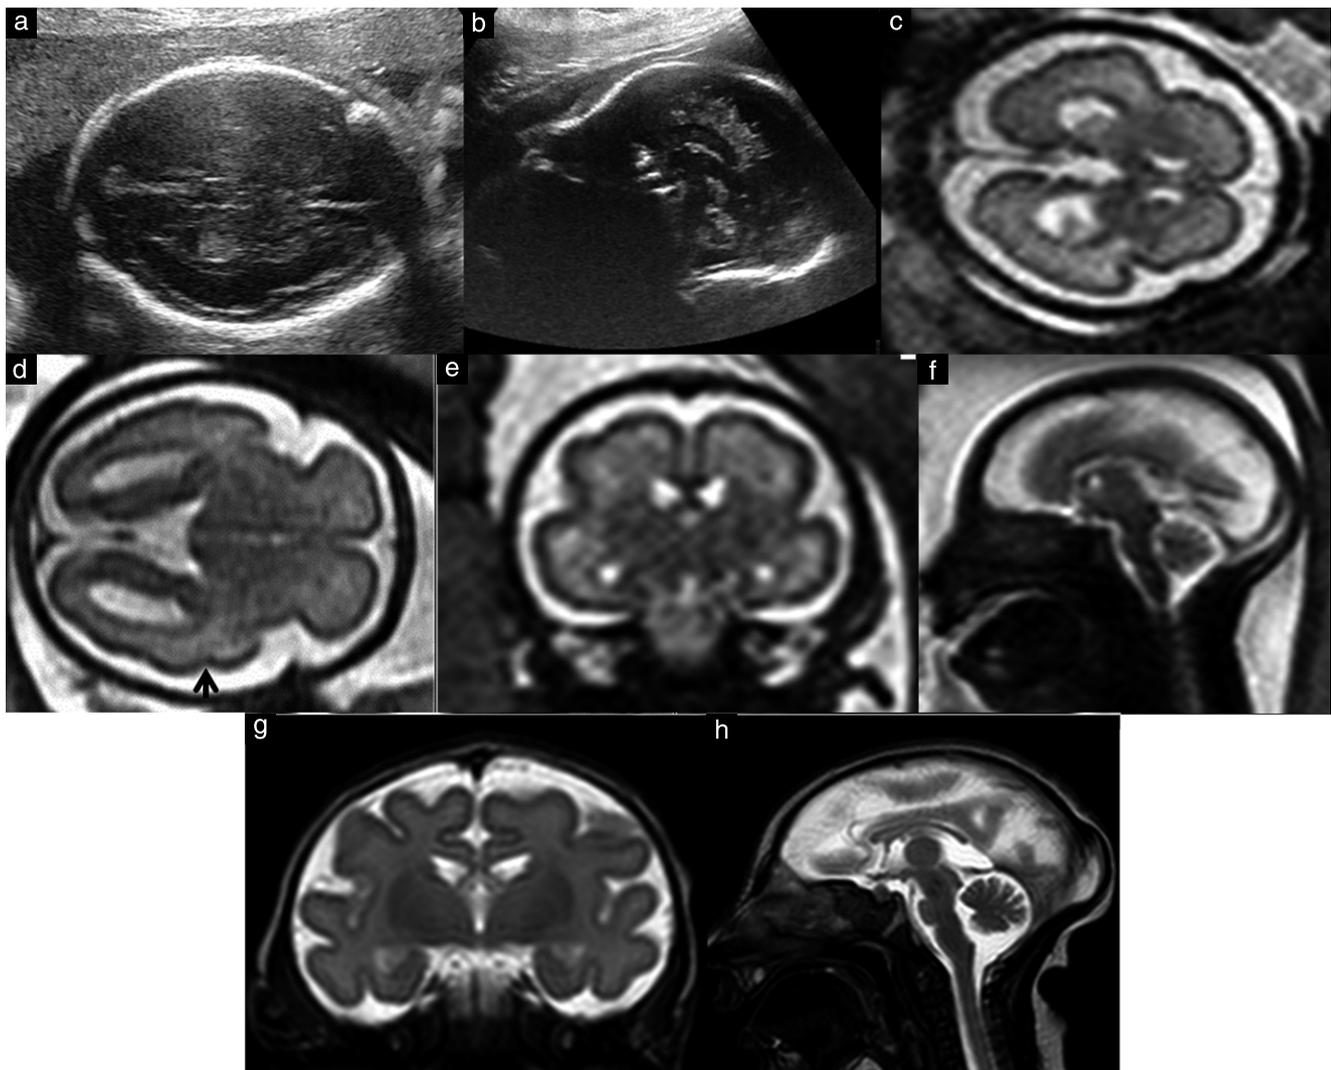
Fetal and postnatal imaging in a patient referred at 26 gestational weeks due to both a decrease in cephalic biometry and non-identification of the corpus callosum, with no context of consanguinity. At first sonographic examination, microcephaly was confirmed, with head circumference (HC) corresponding to the 50th percentile at 23 weeks, equivalent to a decrease of 2.5 SD, associated with normal extracerebral biometry. Axial (a) and mid-sagittal (b) sonographic images showing both smooth cortical surface with a lack of gyral pattern (a) and presence of thin complete corpus callosum (b). Sonographic follow-up at 28.3 weeks demonstrated severe, non-progressive microcephaly (delayed by 3 weeks according to cephalic biometry) without any changes in gyral pattern (smooth cortical surface) on axial sonographic image (not shown). These findings were confirmed on axial (c) and coronal (e) T2-weighted fetal magnetic resonance imaging (MRI), which demonstrated smooth cortical surface, very few sulci and normal thickness of cortical ribbon. Note lack of operculization of Sylvian fissure and absence of superior temporal sulcus (c) compared with control at 28 weeks on axial T2-weighted fetal MRI (arrow) (d), in particular an absence of any anterior margin of the Sylvian fissure related to marked frontal hypoplasia, as stated in Guibaud *et al.*¹⁹. Sagittal T2-weighted fetal MRI (f) confirmed presence of a thin corpus callosum and revealed suspicion of a slight decrease in volume of the pons. Prenatal imaging data were suggestive of microcephaly with a highly simplified gyral pattern. After prenatal counseling, the parents elected to continue the pregnancy despite high probability of poor cognitive outcome. (g,h) Postnatal MRI at 8 days confirmed the diagnosis of microcephaly with a highly simplified gyral pattern (HC, 28.5 cm at term) as well as pontine hypoplasia.
